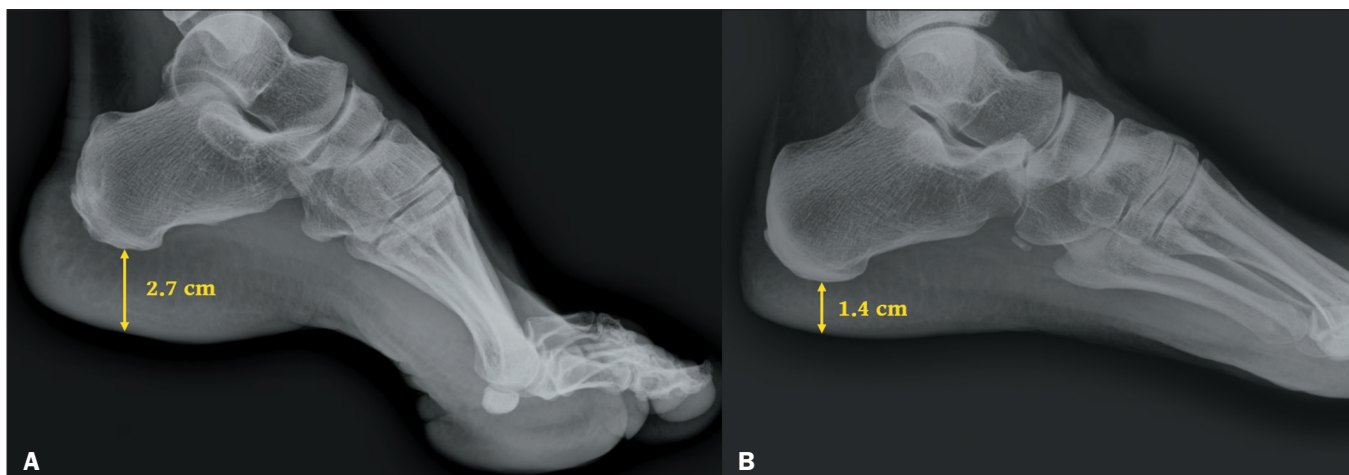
Radiograph of the foot, in a lateral view, showing increased thickness of the plantar fat pad of the foot of a patient with acromegaly (A) compared with that of a healthy patient (B).
